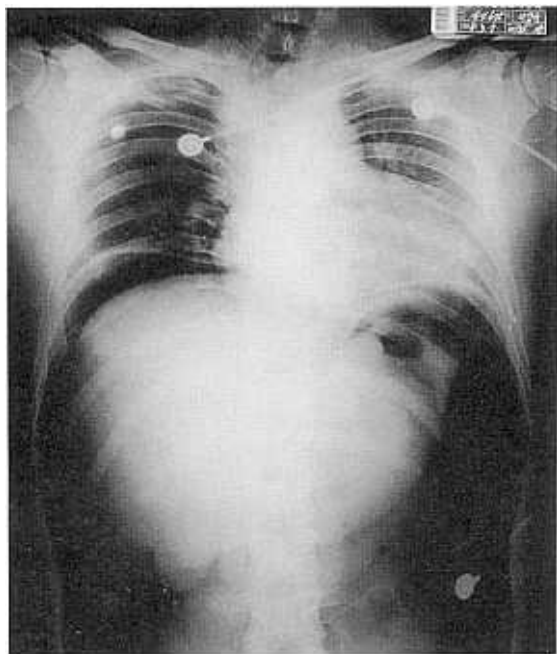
Chest X-ray showing a large amount of intraperitoneal free air.
